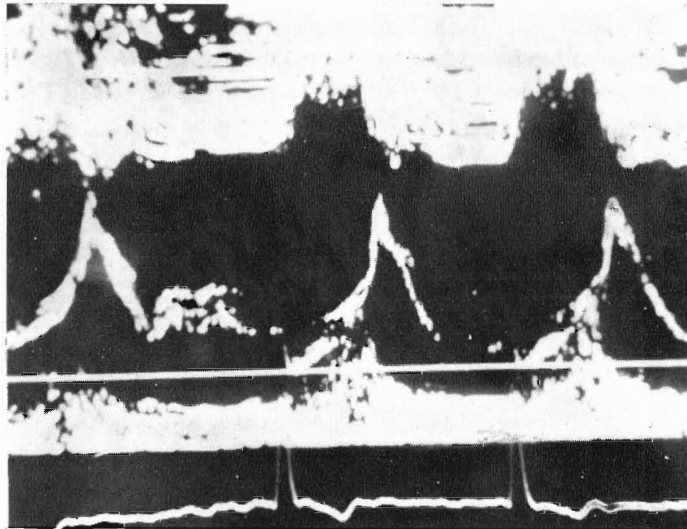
Ultrasound echocardiogram of the tricuspid valve shows the diastolic descent slope of 240.9 mm/sec.
